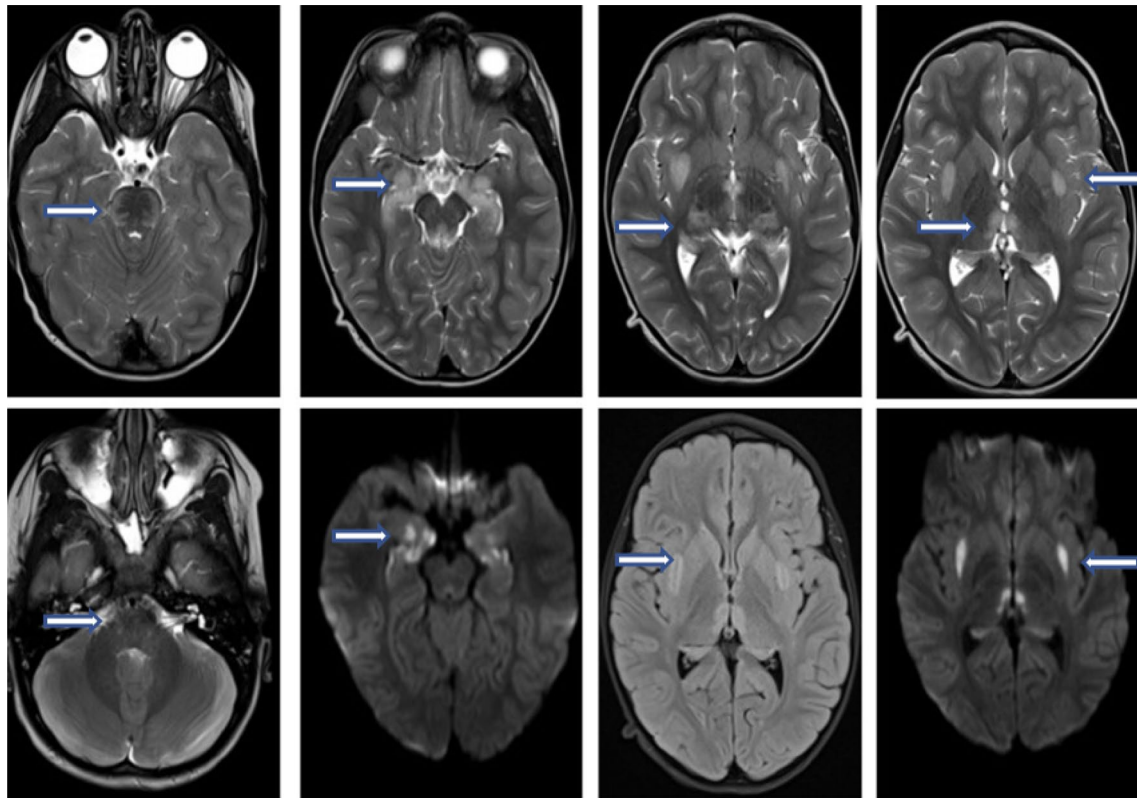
T2- and Flair-weighted images and diffusion MRI of the patient 9. There are extensive signal increases in the bilateral thalamus, external capsule, mesencephalon, temporal lobe, and pons.
